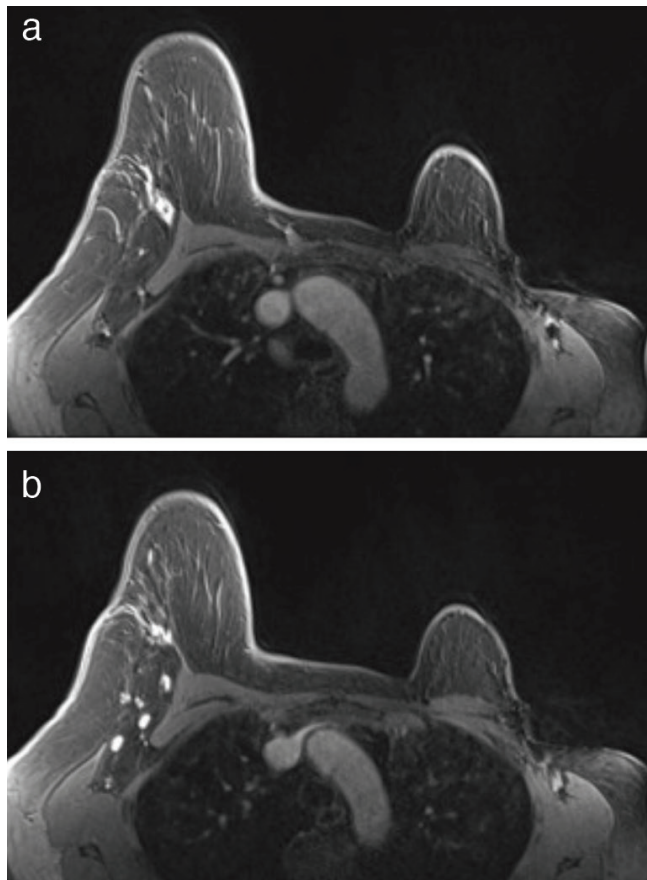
Breast MRI with contrast showing (a) right axillary enhancing mass with a biopsy marker, and (b) several morphologically abnormal right axillary lymph nodes
